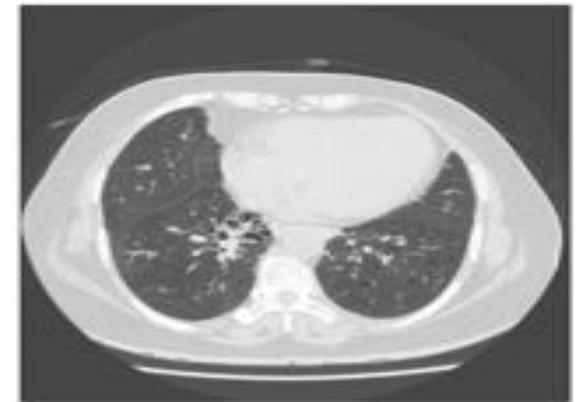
High-resolution computed tomography of an asthma patient with bronchiectasis.
